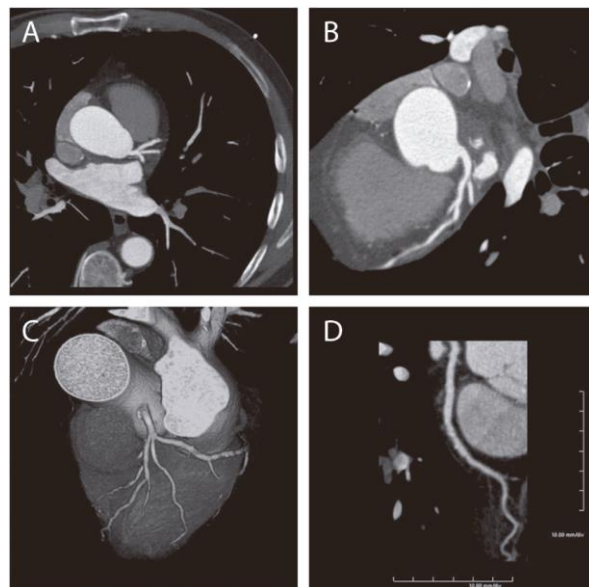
Coronary Computed Tomographic Angiography (CCTA) reconstructions: axial image (A); multiplanar reconstructed image (B); anatomic 3D volume-rendered image; and curved multiplanar reconstruction (D). Adapted from Prat-Gonzalez et al. [43].
